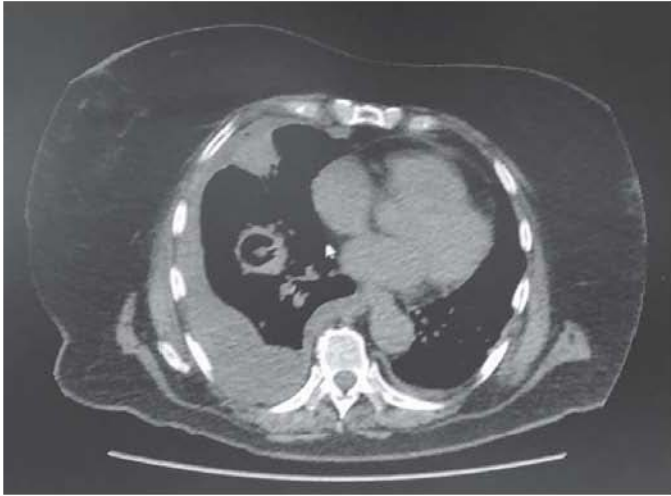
Thoracic CT-scan image of a patient with aspergilloma (soft tissue opacity)
